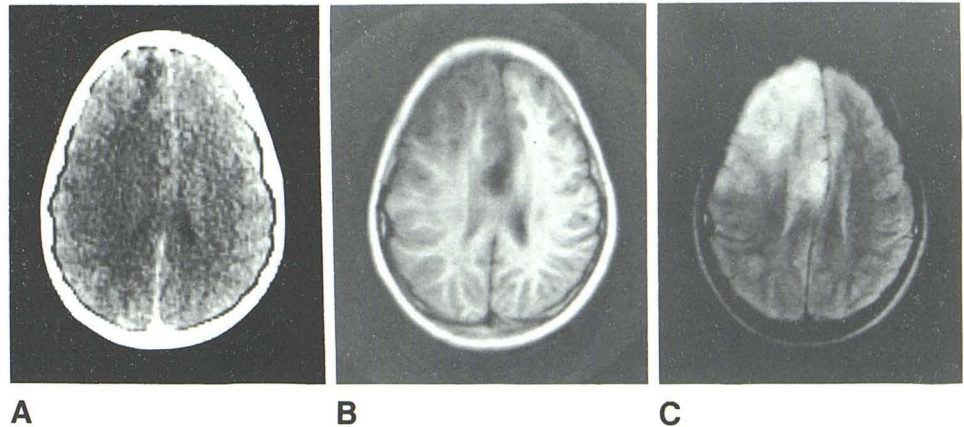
Microglioma. Contrast-enhanced CT (A) and SE 1080/80 (B) scans. Contrast-enhancing lesion in left frontal lobe is surrounded by area of low attenuation; low-attenuation areas are seen also in right frontal and basal ganglia regions (A). Areas of increased T2 are seen in both frontal lobes, right basal ganglia, and both temporoparietal regions as well (B).
